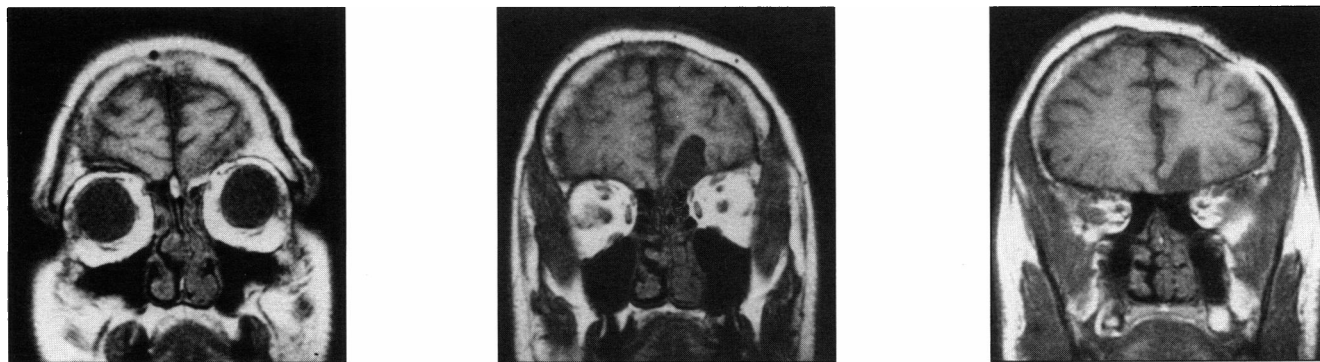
Coronal MRI scans show a wedge-shaped zone of cerebral damage in the left orbitofrontal lobe involving the gyrus rectus and the medial aspect of the orbital gyri. Note that part of the medial cortex of the gyrus rectus is intact.
